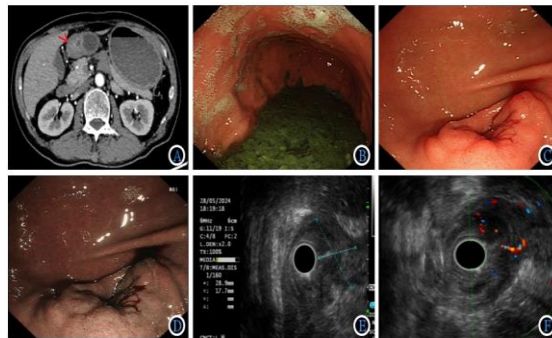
A: Abdominal computed tomography (CT) reveals wall thickening involving the gastric antrum and pyloric region (arrow), suggestive of a submucosal tumor. B: Significant fluid retention within the stomach. C&D: Gastroscopy showing a 2.5 cm mass at the greater curvature with the central depressed area was not clearly visualized. E: EUS showing a hypoechoic lesion measuring approximately 28.9 \times 17.7 mm, protruding into the gastric lumen and infiltrating the muscularis propria. The serosal layer was not involved. F: Color Doppler imaging demonstrated punctate internal vascular signals.
